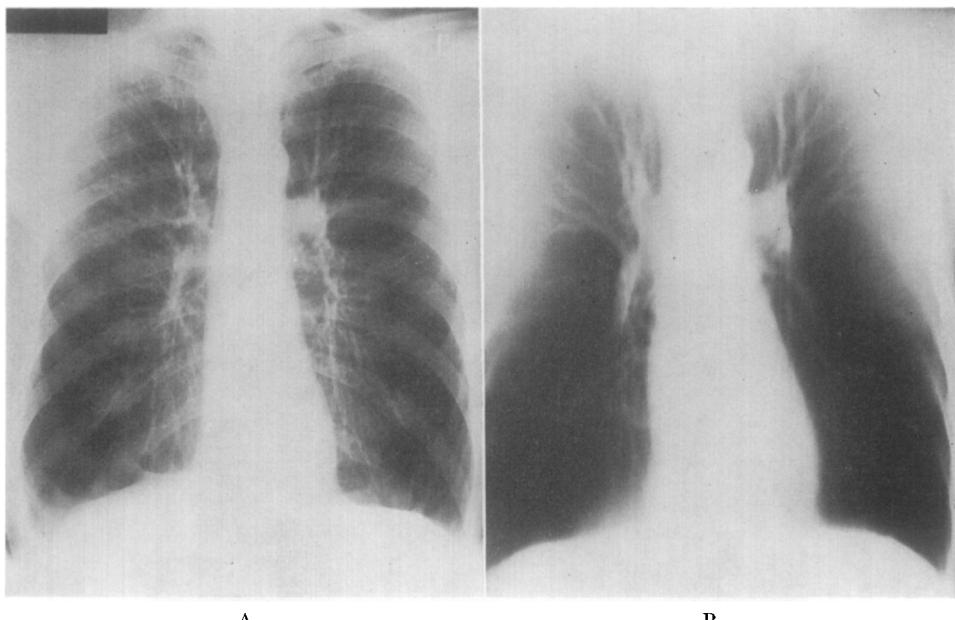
A, Postero-anterior chest radiograph in full inspiration. B, Whole lung tomogram (13 cm cut). The patient was a male aged 45 with  $\alpha_1$ -at deficiency and severe emphysema. The lungs are overexpanded, with vascular attenuation at both bases. (Reproduced by kind permission of the Editor of the *British Medical Journal*)
